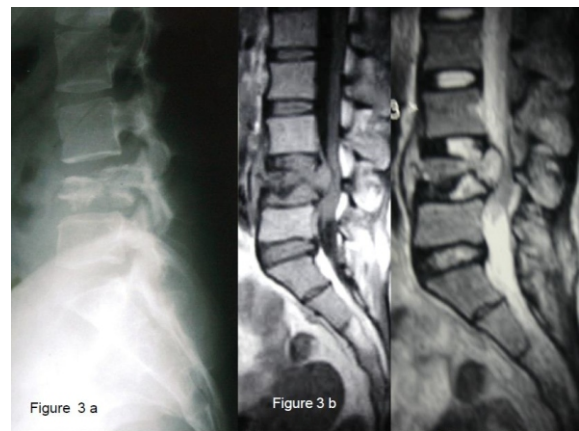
a: X-ray of lumbar spine (lateral view) of patient # 14 showing destruction and fragmentation of L4 vertebral body and resulting kyphus. 3 b: The saggital T1, T2 MR images show severe dural indentation.
